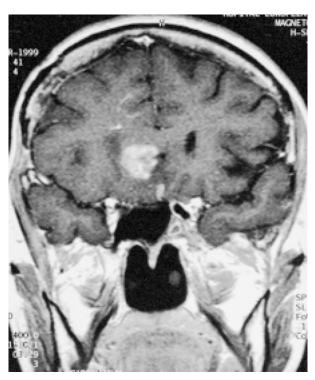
Magnetic resonance imaging scan of the brain. Coronal T1 weighted with gadolinium. Right frontal mass (metastasis).
